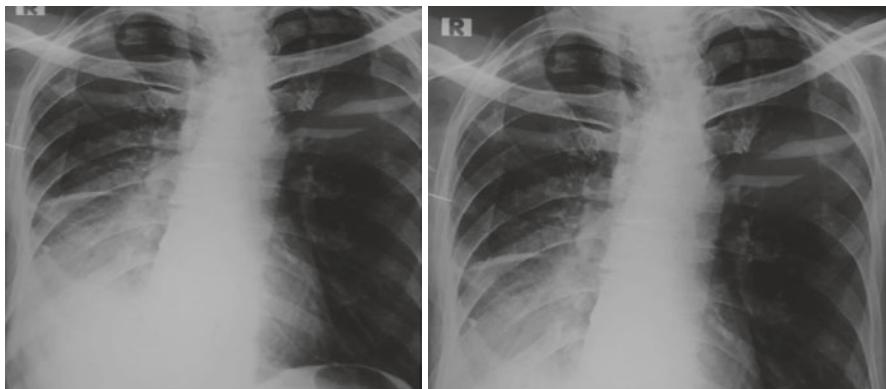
Chest X-ray revealing right-sided lower zone opacity with fluid in the fissure
